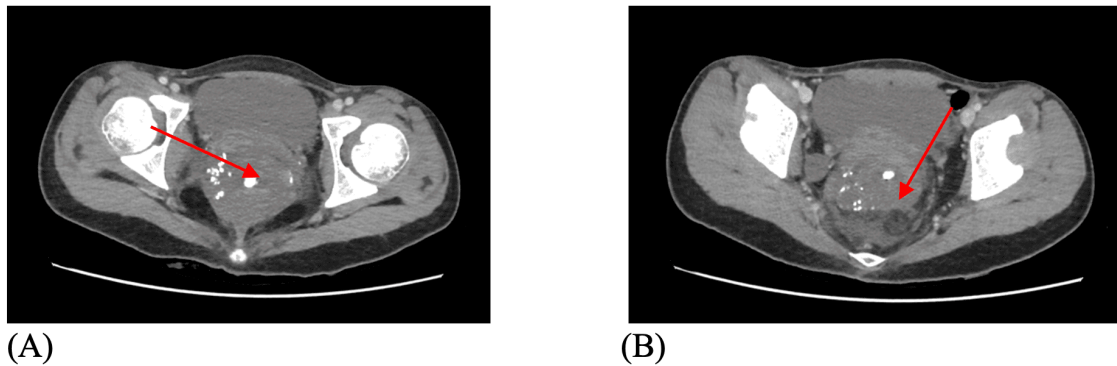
Abdominal contrast CT shows the mass. (A) Mass in the rectum with contrast enhancement. (B) Arrow pointing at the narrowed rectal lumen
